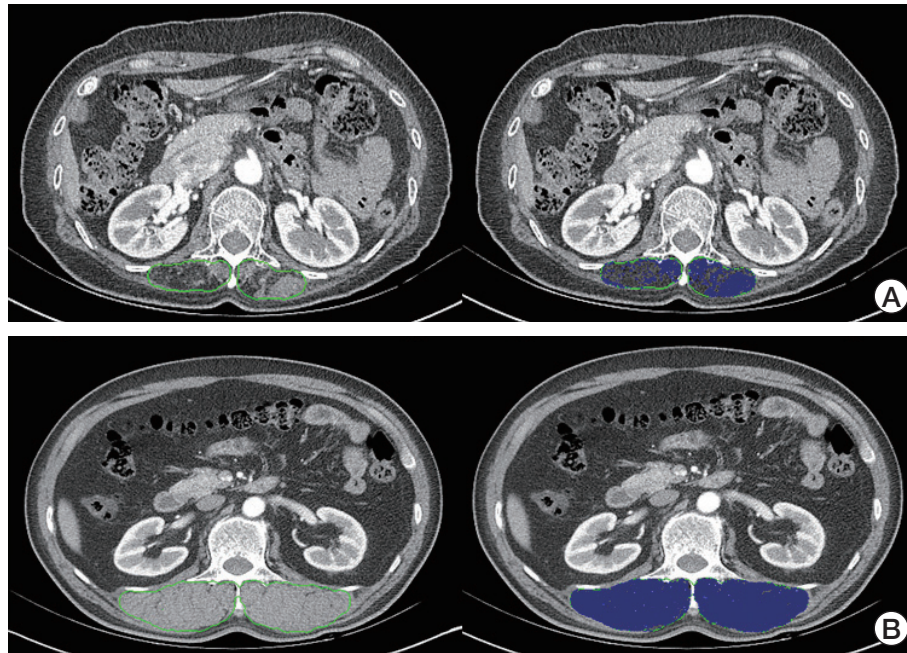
HU_{ESMcsa} calculation. We drew the erector spinae muscles (first lumbar level) with a green line. For each computed tomography image, we calculated the muscle thresholds. The software program calculated the HU_{ESMcsa} (indicated in blue). (A) Muscle atrophy: HU_{ESMcsa} 975.8 cm^2 . (B) Muscle hypertrophy: HU_{ESMcsa} 5,910.1 cm^2 . HU, Hounsfield unit; HU_{ESMcsa} , Hounsfield unit of average intensity value of erector spinae muscle in cross-sectional area in computed tomography.
